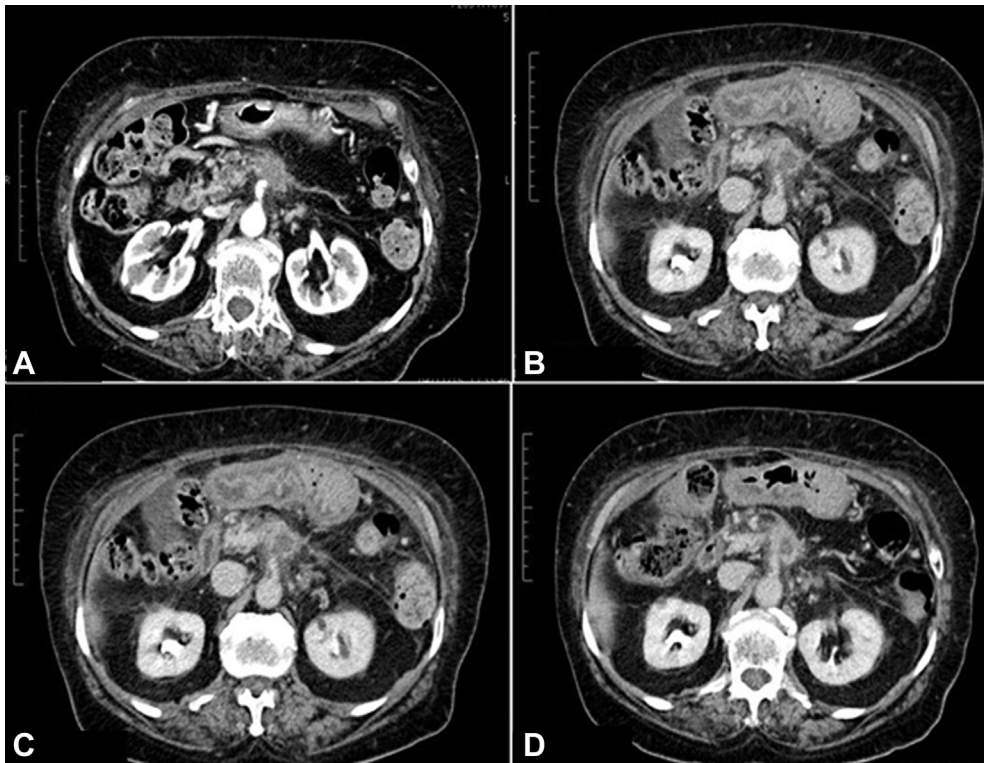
A, CT scan: pretreatment arterial phase showing a focal lesion of the pancreatic body, adjacent to the mesenteric artery with infiltration signs. Delayed phase showing the coagulation area in the body of the pancreas, well demarcated by a rim of postcontrast enhancement at 24 hours (B), 7 days (C), and 30 days (D). Power setting, 4 W, 1000 J, 250°.
